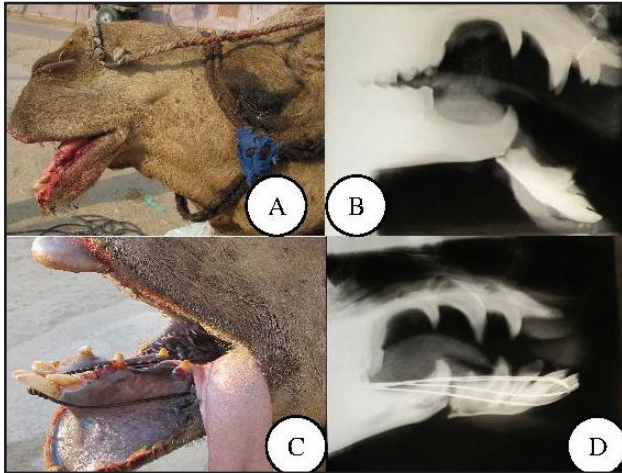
(A) Mandible fracture in a camel. (B) A latero-medial radiograph of camel showed transverse mandible fracture at the alveoli of tushes. (C) Mandible fracture was repaired by interdigital wiring technique. (D) A latero-medial radiograph of mandible of camel showed immobilisation with interdigital wiring. Note the slight overriding at fracture site.
